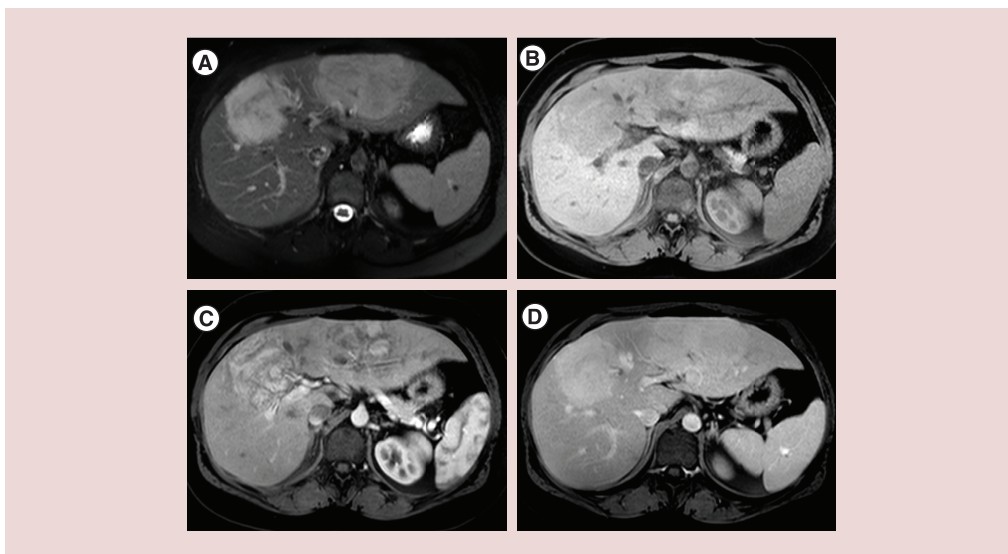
Imaging features of inflammatory hepatocellular adenoma. Two large inflammatory hepatocellular adenomas in a 33-year-old woman. Note: typical MRI appearance with marked hyperintensity on T2-weighted images (A), together with hypointensity on T1-weighted fat-suppressed images (B). After contrast medium injection, there is strong heterogeneous arterial enhancement of the two lesions (C) that persists in the portal venous phase (D).
